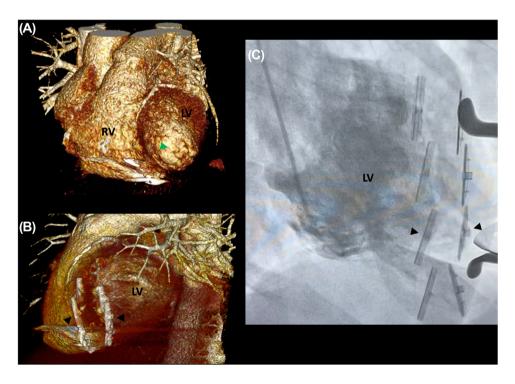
(A) Preoperative 3D volume rendering CT of a patient with distal antero-lateral and apical scar (green arrowhead); (B) postoperative 3D volume rendering CT of the same patient with three LV-LV anchor pairs deployed, demonstrating full scar exclusion; (C) postoperative LV ventriculography of patient with lateral LV scar, treated with four linear LV-LV anchor pairs (black arrowheads pointing to an anchor pair). LV, left ventricle; RV, right ventricle
